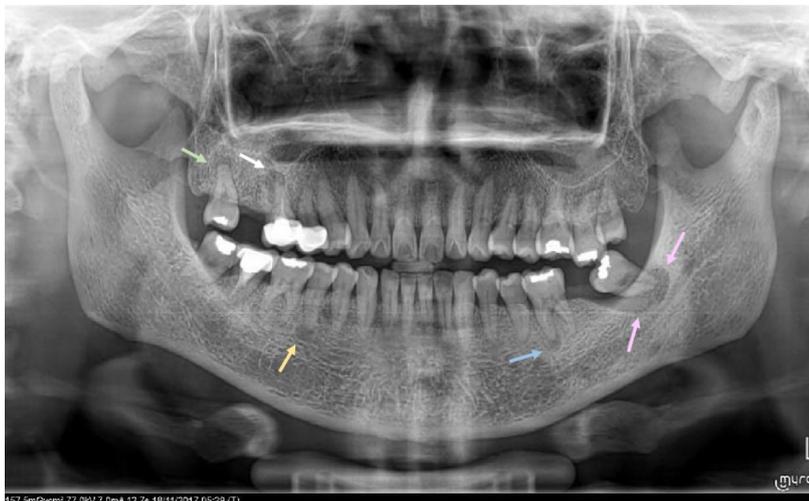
Orthopantomogram on Nov 18, 2017(Day 1) of the patient showing gross bone loss around apical region of 38(lower left third molar) and apical radiolucency around 36(lower left first molar) mesial root. There were 5 sites of apical radiolucency.
